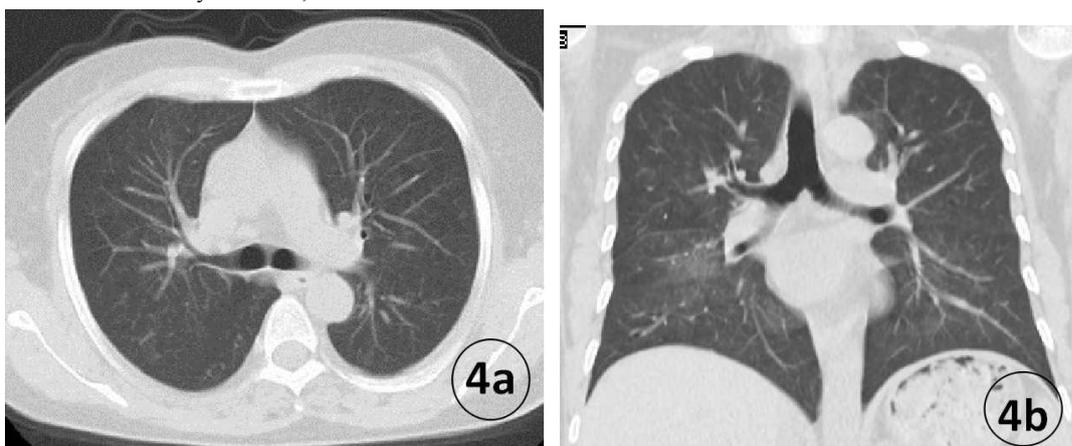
Axial and coronal unenhanced chest CT images after two weeks' treatment show the lesions totally absorb amid lung parenchyma.
